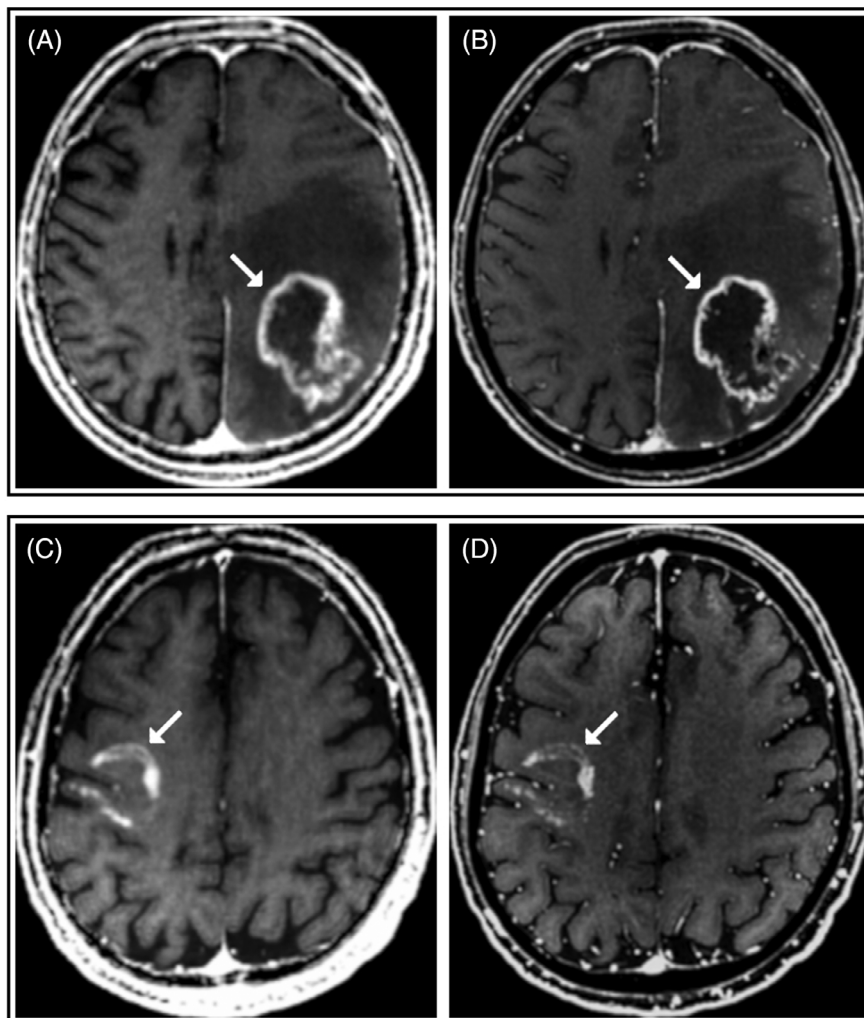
Synthetic (A and C) and conventional (B and D) post-contrast T1-weighted images in two patients with intra-axial brain tumors. Panels A and B show images of a patient with a large glioblastoma involving parietal, temporal, and occipital lobes of the left hemisphere. Panels C and D show images of a patient with a diffuse astrocytoma in the frontal and parietal lobes of the right hemisphere. In both patients, synthetic imaging (A and C) reveals the pathological enhancement of the tumoral mass (arrows) and reflects the inhomogeneous pattern of enhancement visible at conventional imaging (arrows in B and D).
